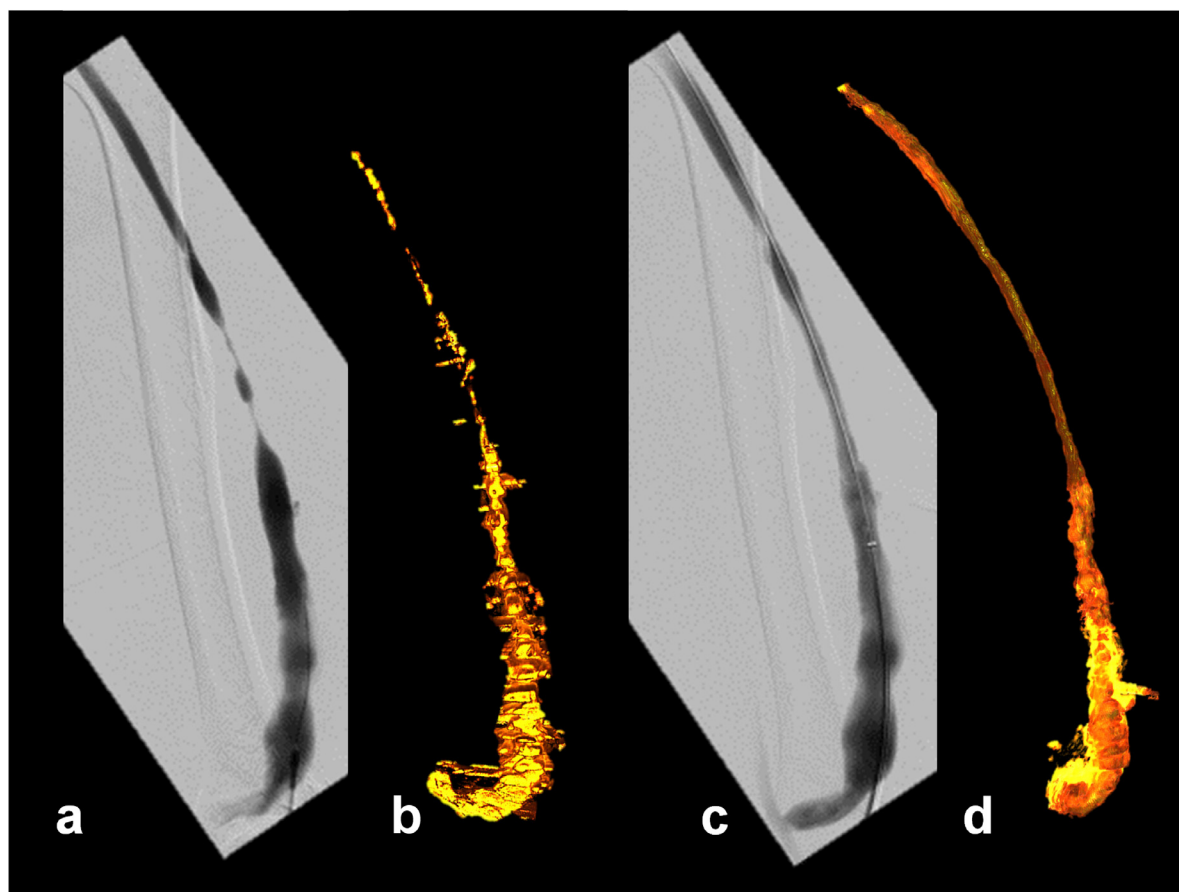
3-D tomographic ultrasound images and angiographies of an arteriovenous fistula (AVF) with a high-grade stenosis before and after balloon dilation. (a) Angiography of the AVF with a high-grade vein stenosis. (b) Corresponding 3-D tomographic ultrasound image on the basis of power Doppler of the AVF with the small diameter of the remaining lumen of the vein. (c) Angiography of the AVF after balloon dilation. (d) Corresponding 3-D tomographic ultrasound image of the AVF showing good agreement after successful dilation of the vein stenosis.
